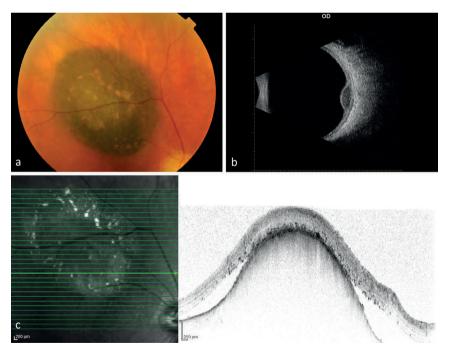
A dark pigmented uveal melanoma with orange pigment. Figure 3b. On B-scan ultrasonography, acoustic hollowing and choroidal excavation is present. Figure 3c. Subretinal fluid and retinal pigment epithelial alterations are visible on optical coherence tomography scan at the top of the tumour.
